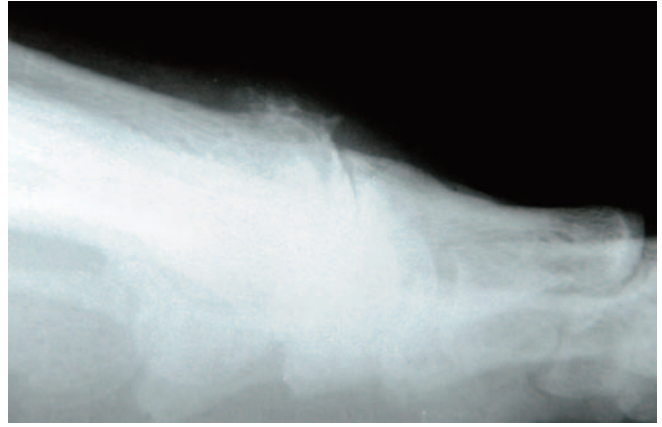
Case Study 1. Preoperative lateral radiograph.
